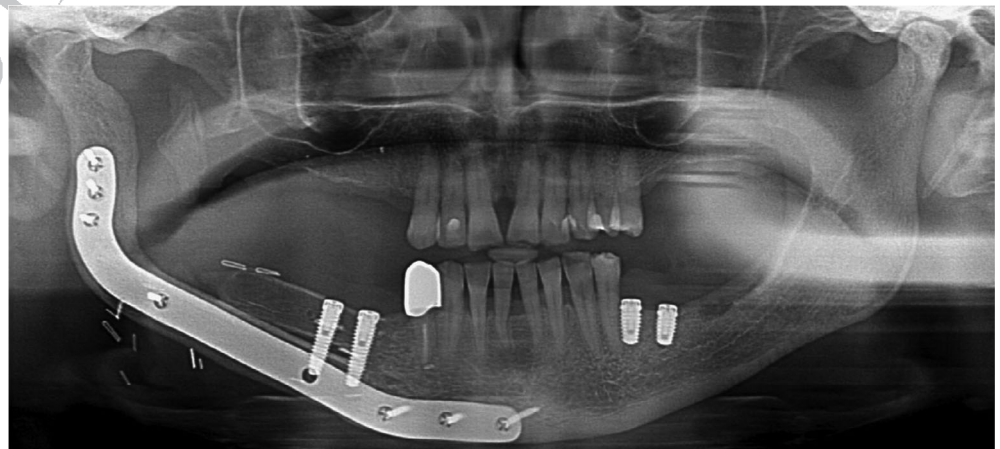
Panoramic radiograph of a patient with two dental implants inserted in free fibular flap and two dental implants inserted in native bone
